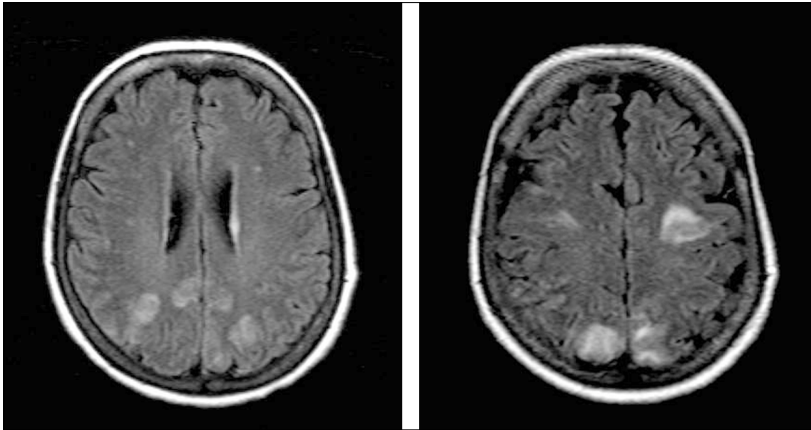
Axial FLAIR MRI showing posterior reversible leucoencephalopathy
